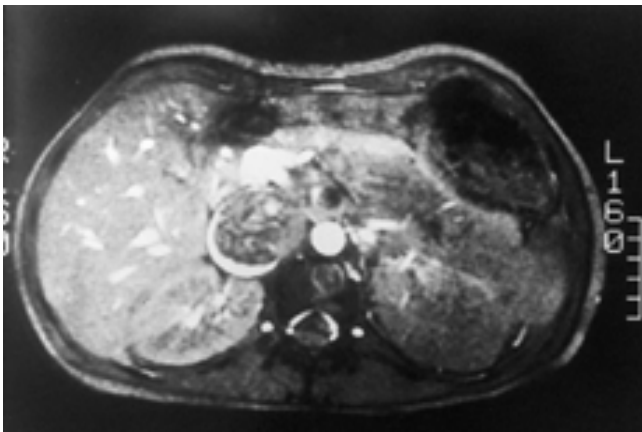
Axial magnetic resonance imaging view showing left renal mass with caval extension and surrounding contrast material.
